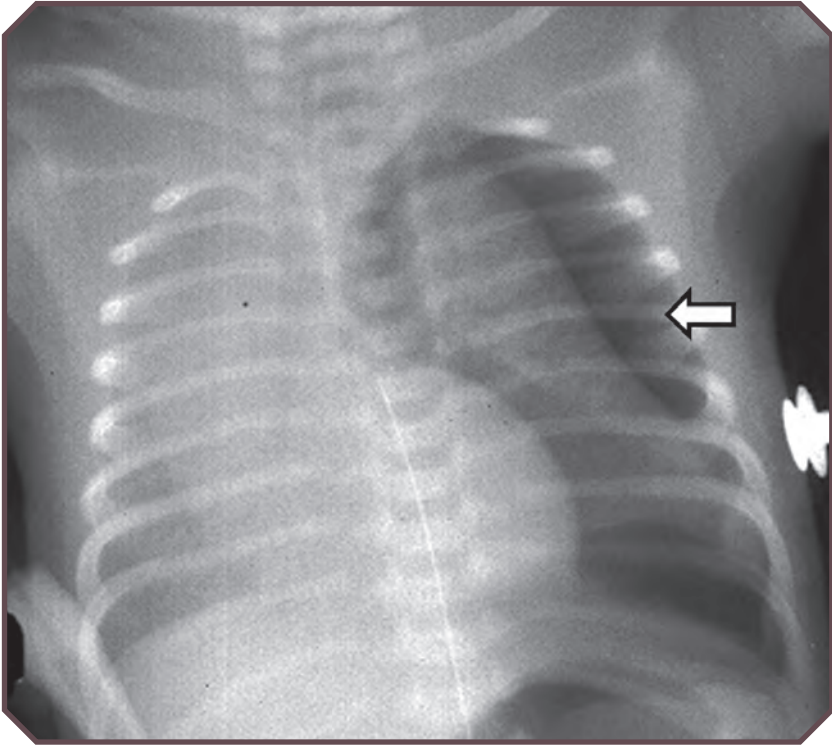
Frontal portable radiograph obtained in a premature newborn with surfactant deficiency and worsened respiratory distress shows diffuse fine granular alveolar opacities, in addition to a left pneumothorax (arrow). Also, noted is a small amount of left-to-right shift and an umbilical catheter.
